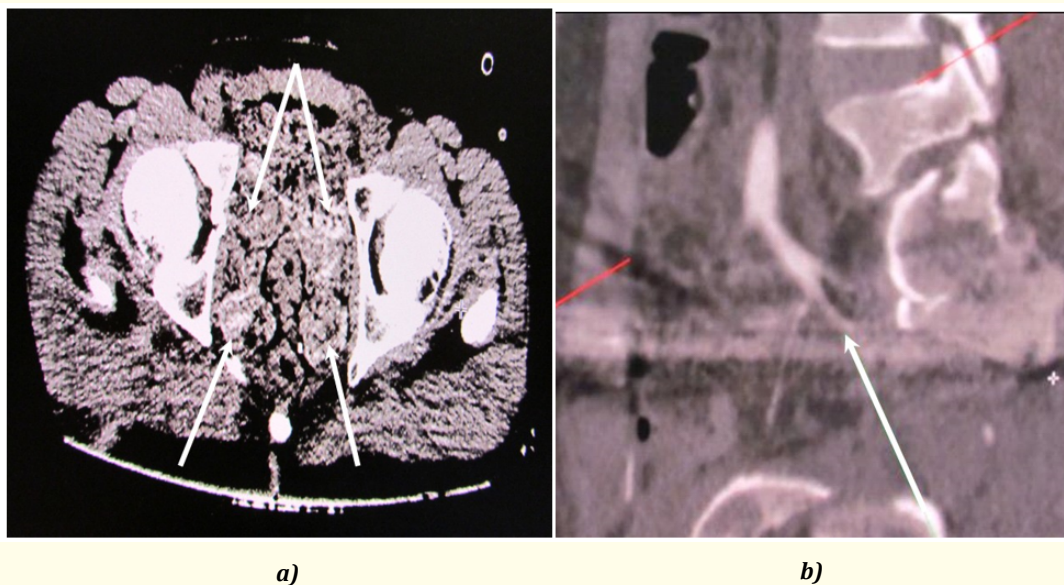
CT of the pelvis with intravenous contrast: a - axial section at the level of the acetabulum (arrows indicate tampons); b - a break in contrast at the level of the anterior trunk of the right internal iliac artery (indicated by an arrow).
